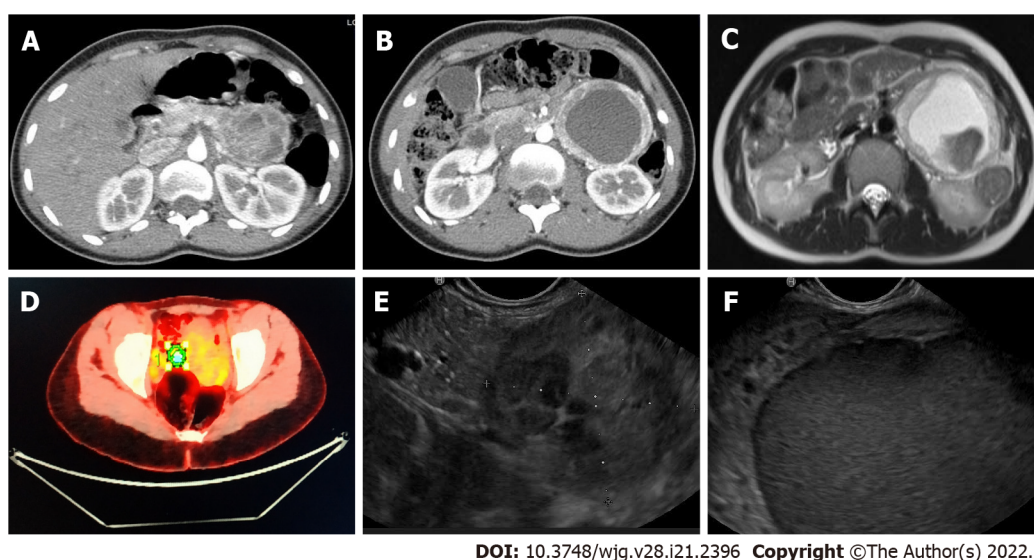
Radiologic findings. A and B: Computed tomography-scan showed a 95-mm cystic lesion with no cleavage plane from the pancreas; C: Nuclear magnetic resonance evidenced that the lesion was hyper-intense in T1; D: Positron emission tomography demonstrated a 4.7% standard uptake value; E and F: Endoscopic ultrasonography identified a hypoechoic mass close to the pancreatic tail.
